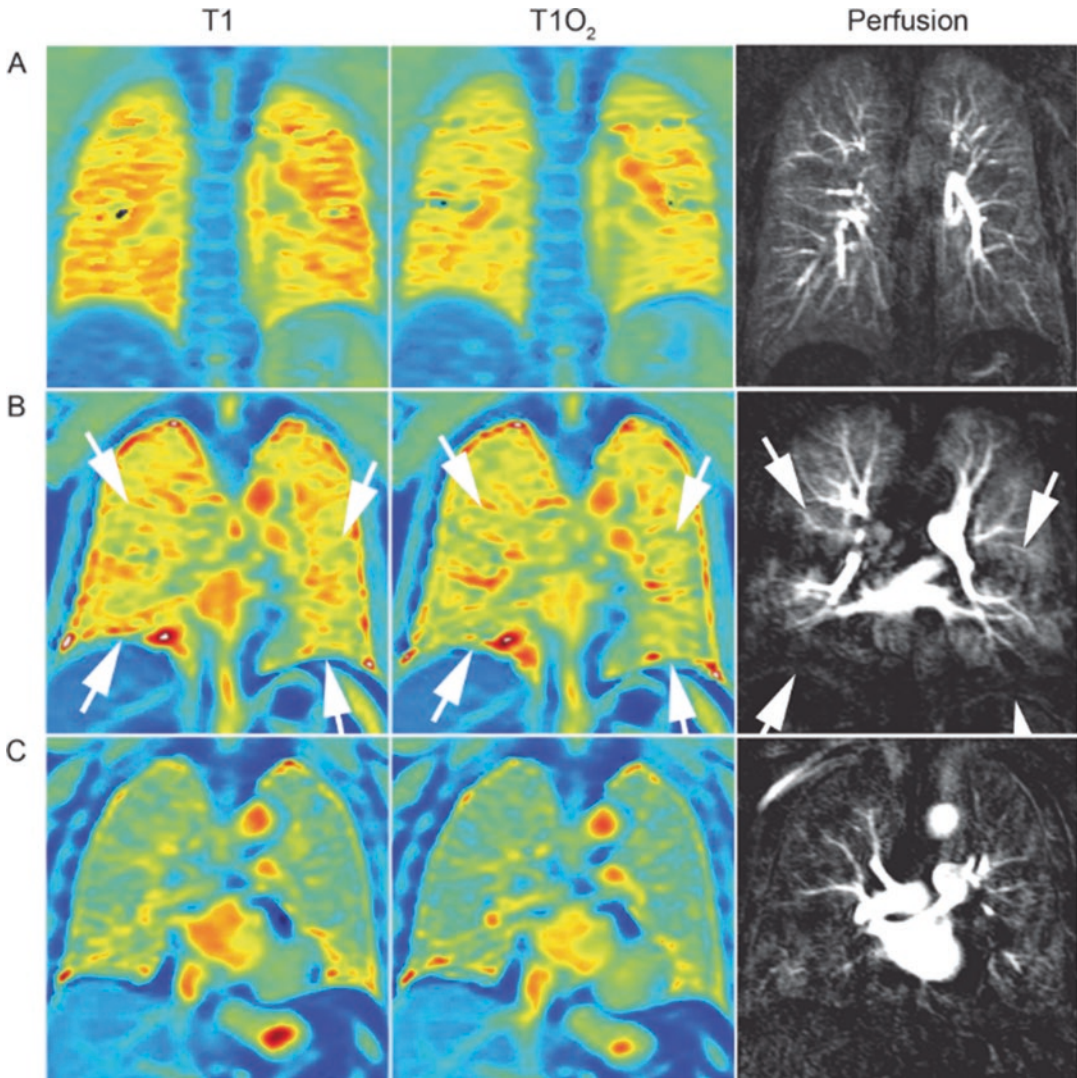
OE-MRI T1 maps and DCE perfusion MRI. Coronal views of three subjects: (a) healthy subject, (b) and (c) COPD. Reduction in oxygen-enhanced signal with 100% oxygen (T1O₂). Signal is significantly diminished in COPD subjects. Minor ventilation and perfusion
